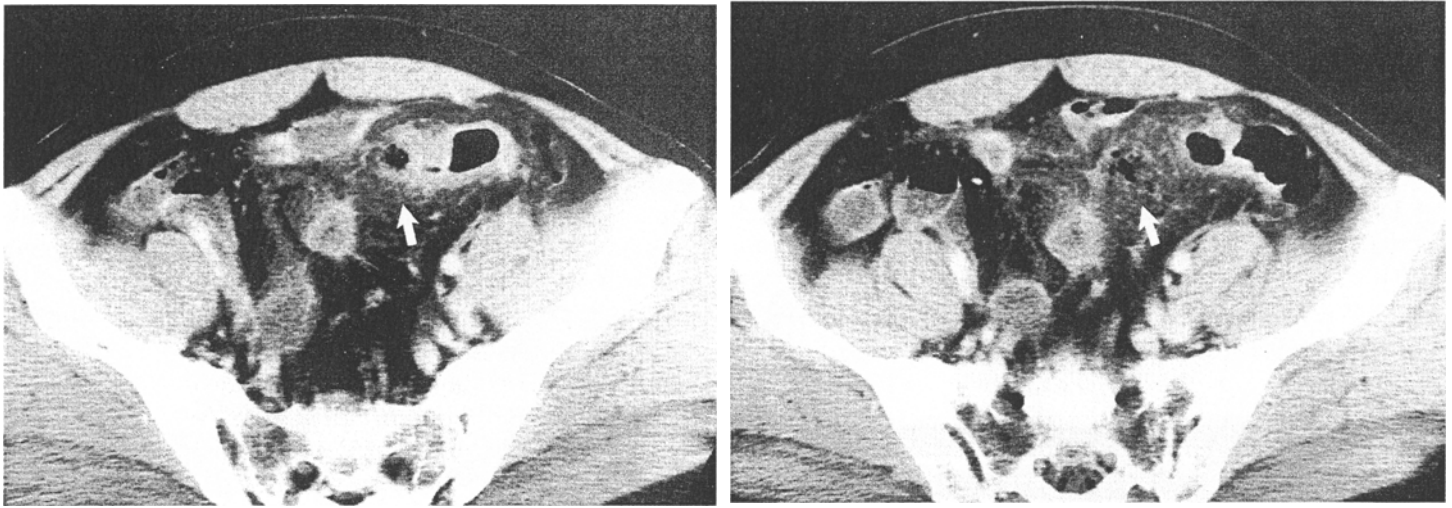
50-year-old man with spontaneous perforation of sigmoid colon. Left and right, two continuous CT sections reveal the small size of the dirty mass (arrow) near the sigmoid colon. The dirty fat sign is obvious around the dirty mass.
